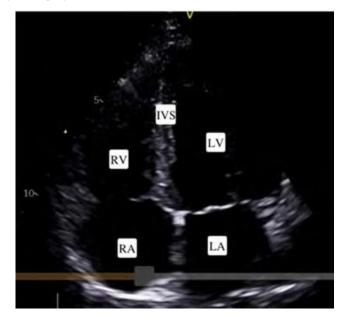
An apical 4 chamber view obtained with a phased array transducer in the left fifthintercostal space, with the probe marker corresponding to the patient's right. Abbreviations: RA (right atrium), LA (left atrium), RV (right ventricle), LV (left ventricle) and IVS (interventricular septum).
